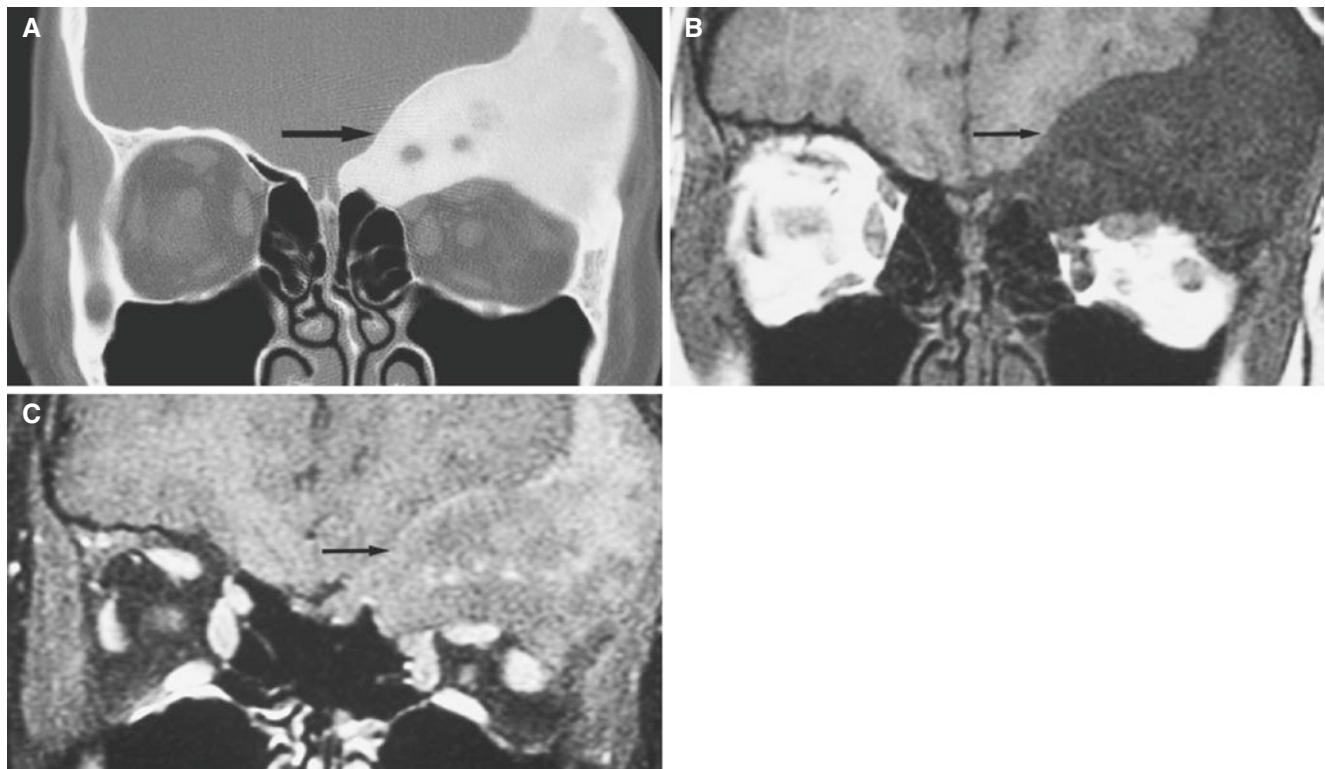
Fibrous dysplasia; 17-year-old presents with painless prominence in left supraorbital region. (A) Coronal CT image shows dense expansile greater wing of the sphenoid bone on the left side. Orbital cavity is compressed (*arrow*). (B) T1-weighted MRI shows
